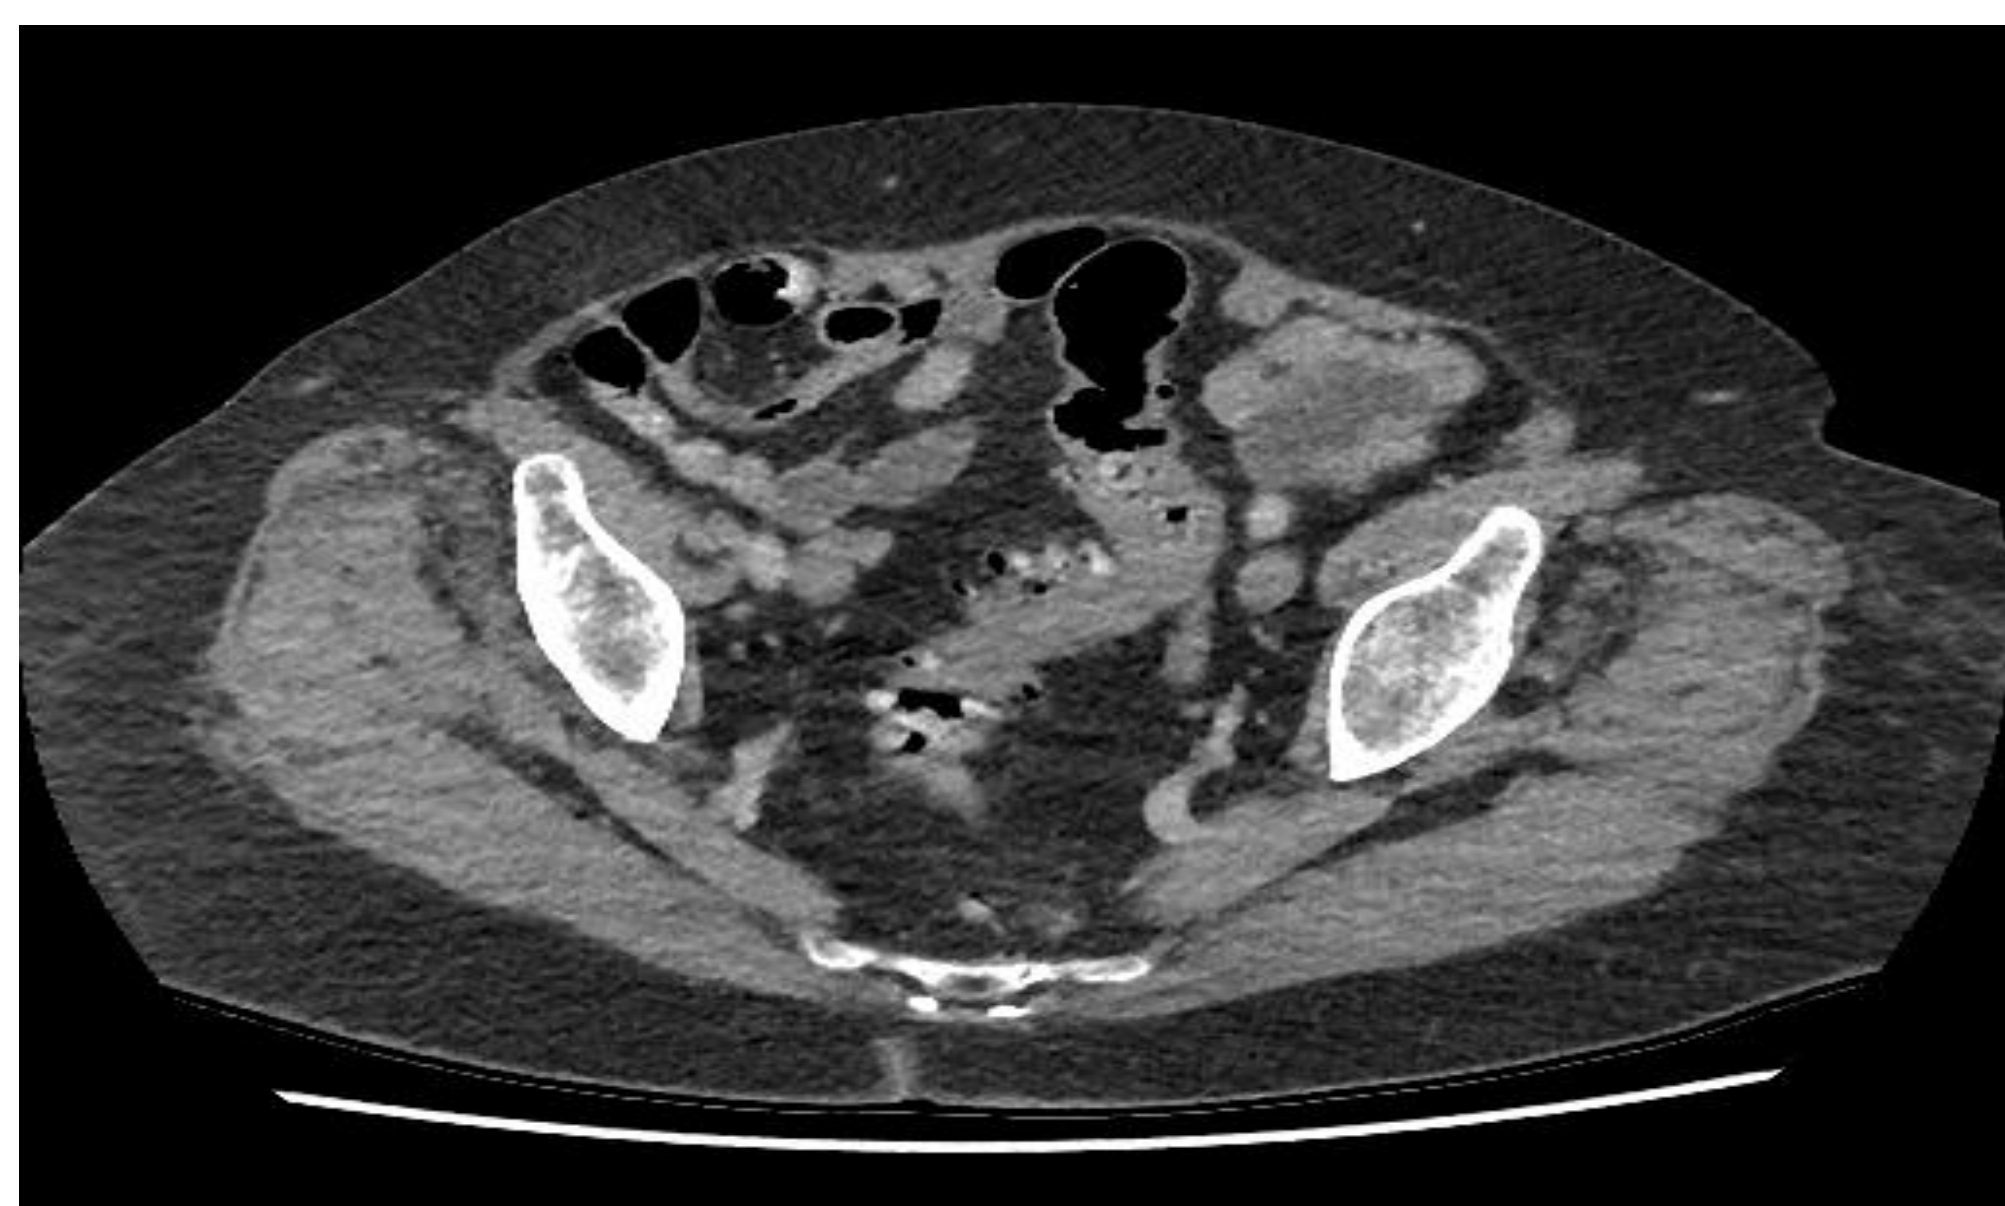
CT abdomen and pelvis- diverticular disease of the large bowel especially affecting the sigmoid colon with appearances suggestive of possible minor diverticulitis of the sigmoid colon
